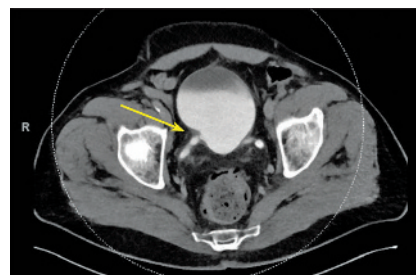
CT urogram demonstrating right bladder wall suspicious for urothelial carcinoma (arrow).
